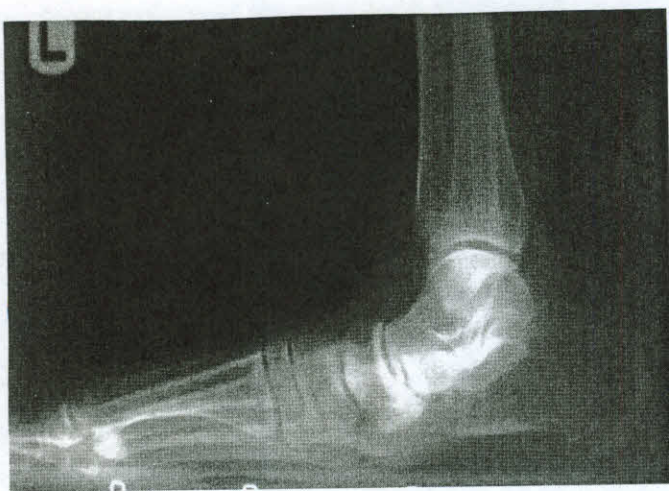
Preoperative lateral radiographic view of a patient's left foot in weight bearing.
